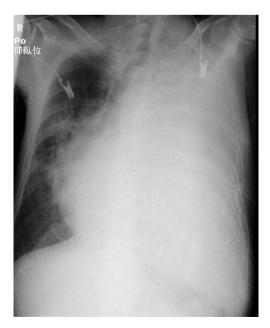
Chest roentgenogram showing decreased permeability in the left lung field and the deviated trachea.
